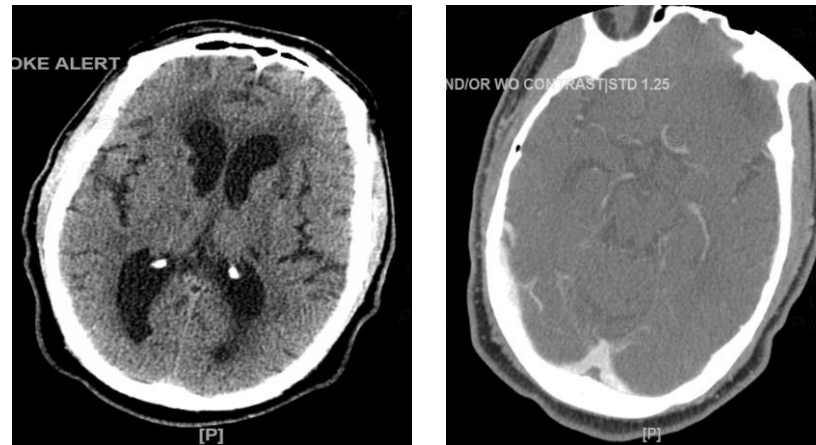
shows CT head with old small lacunar infarcts
